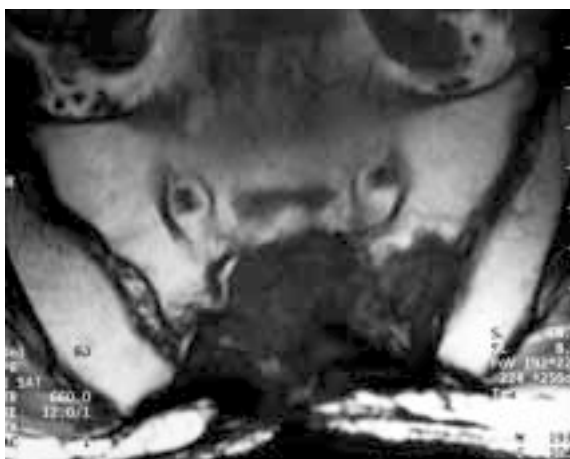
Unenhanced axial T1-weighted MR image of the same patient as in Fig. 8a done three years following an incomplete resection of the tumour. There is marked tumour recurrence with signal intensity similar to the surrounding musculature.
